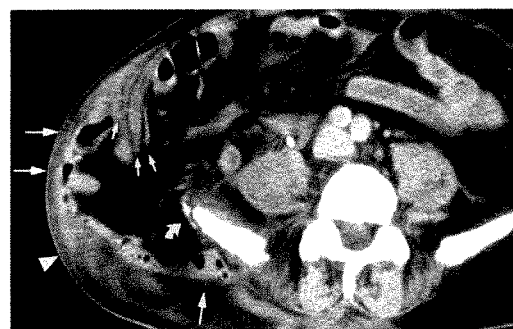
CT scan in a 78-year-old man who was a restrained driver in a motor vehicle accident reveals herniation of bowel (*long straight arrows*) through torn layers (medial to lateral) of transversus abdominis, internal oblique, and external oblique muscles (*short straight arrows*). A right flank hematoma (*arrowhead*) and an avulsion fracture of right iliac crest (*curved arrow*) are also present.
